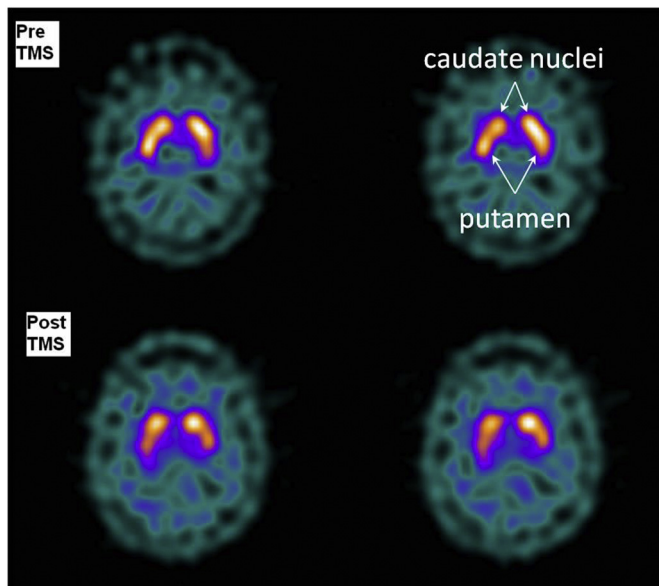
Dopamine Transporter availability in a patient with Gambling Disorder (GD) before and after rTMS treatment. 123 I-FP-CIT SPECT images: transaxial slices showing striatum (caudate nucleus and putamen) radioligand uptake in a GD subject before and after rTMS treatment. The 123I-FP-CIT tracer uptake is correlated to DAT availability. The patient received two weeks (five days twice a day, for a total of twenty sessions) of high frequency rTMS over the dorsolateral prefrontal cortex. In comparison with baseline (PreTMS), the GD patient displayed reduced radiotracer uptake in the bilateral striatum, correlated to reduced DAT availability, after rTMS treatment (PostTMS).
